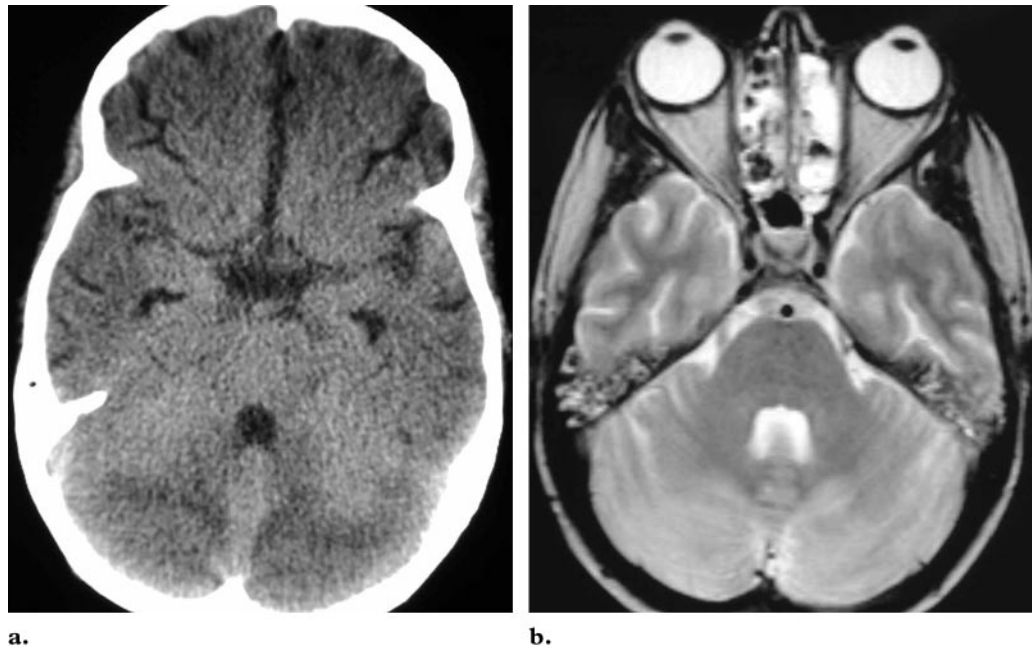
Reversible posterior leukoencephalopathy with cerebellar involvement in a 10-year-old boy with ALL and a bone marrow transplant who presented with posterior headaches and cerebellar signs. (a) Axial CT scan shows symmetrical hypoattenuating cerebellar lesions. (b) Axial T2-weighted MR image obtained 24 hours later shows improvement of the lesions.
